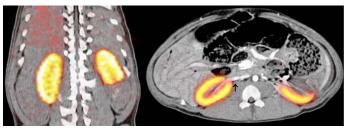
Left kidney infarction. Coronal and transverse fused *PET-CT-slice at the level of the ligated artery. Color (PET)* represent function (*GFR*). Arrow: *CT-contrast filling of a large artery supplying kidney cortex where the glomerular filtration takes place.*
